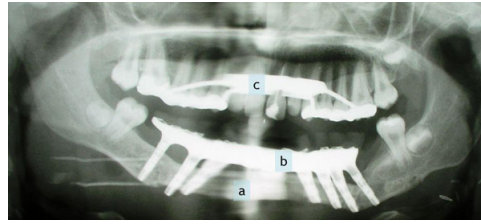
Postoperational orthopantomography after tumor resection in the mandible. Reconstructed mandible with fibula graft (a), 8 implants and fixed Procera®-implant-bridge (b). In the upper jaw: Extension of the maxilla with Memory®-screws (c).
